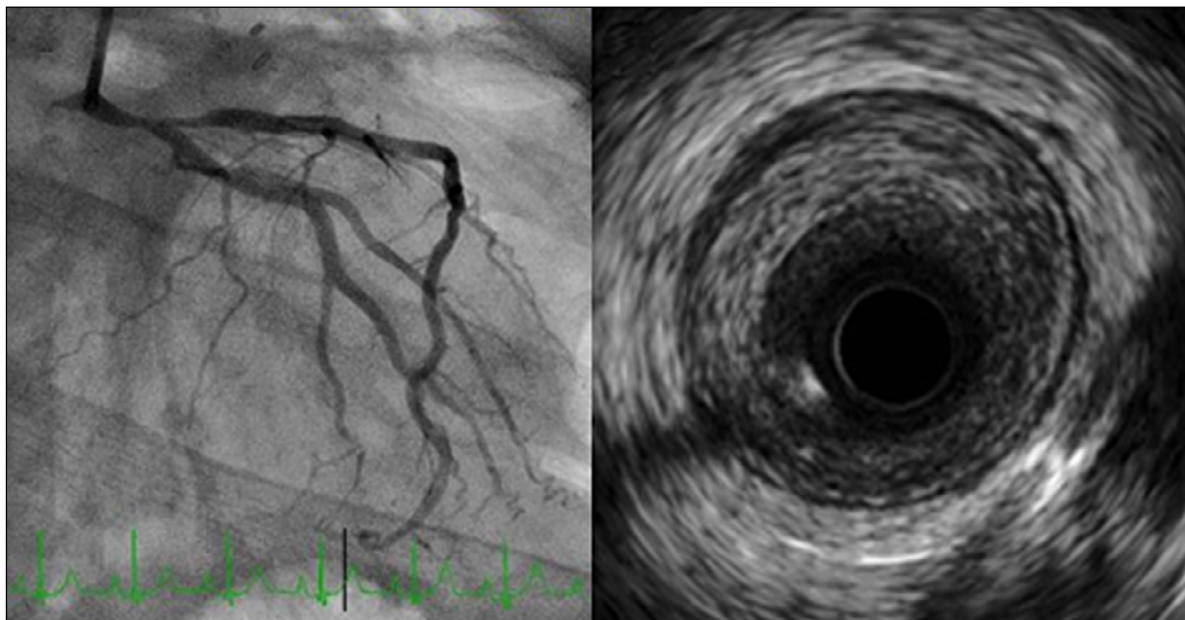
(Left) Coronary angiogram showing severe stenosis of the distal left main coronary artery that extends into the proximal left anterior descending artery. (Right) Intravascular ultrasound image of the distal left main coronary artery showing significant stenosis with circumferential fibrotic plaque without calcification.
